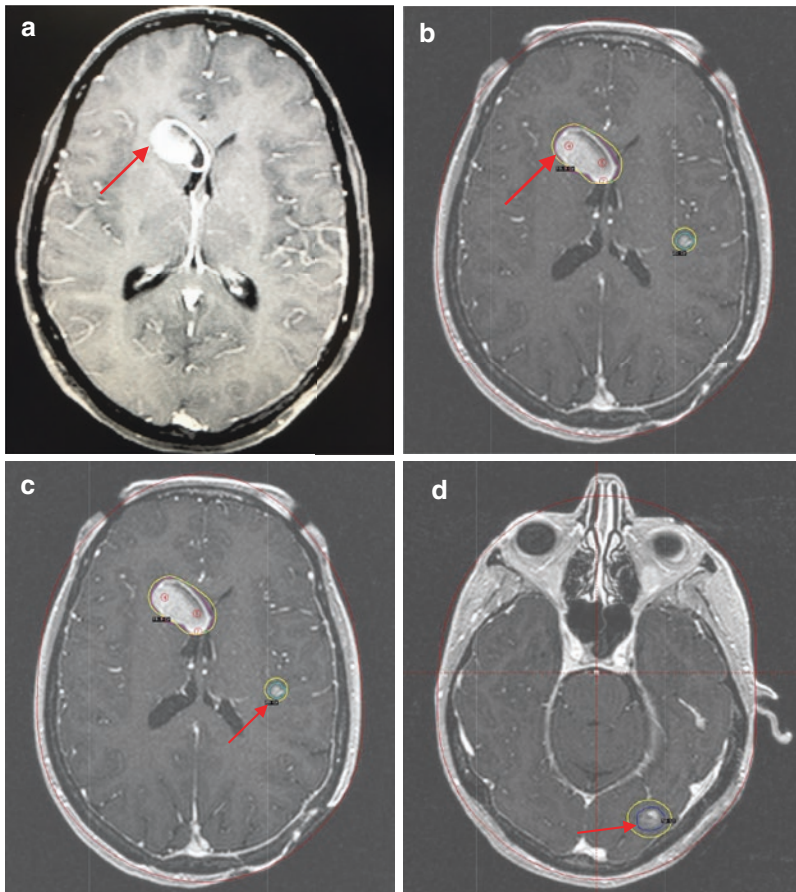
Serial Brain MRI images for Case Report: (a) Initial MRI shows largest of 3 brain metastases, 12-06-2006; (b) Gamma Knife plan for right frontal brain metastasis, 12-13-2006; (c) Gamma Knife plan for left frontal brain metastasis, 12-13-2006; (d) Gamma Knife plan for left occipital brain metastasis, 12-13-2006; (e) MRI 9
